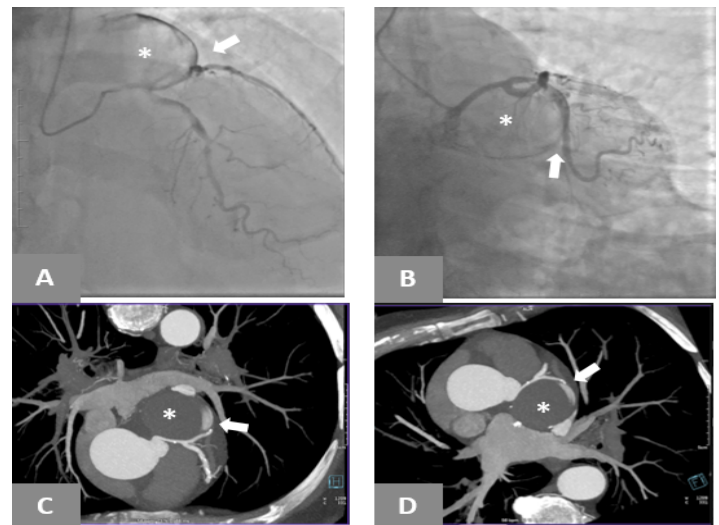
Multimodality imaging. Cranial and right-oblique frame projections from the coronary catheterization (panels A and B) and corresponding Maximal Intensity Projection Frames from the CCTA (panels C and D). The location of the pseudoaneurysm is labeled with an Asterisk (*) and the origin of the ruptured calcified plaque in the proximal LCx artery causing contrast leakage is labeled with a white arrow. CCTA: Coronary Computed Tomography Angiography. LCX: Left Circumflex.
